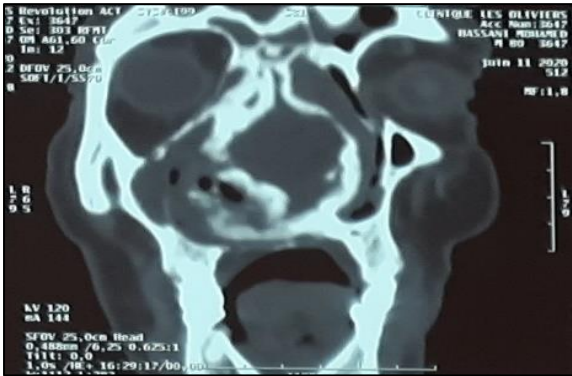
Computed tomography demonstrate the total obstruction of nasal airway.
